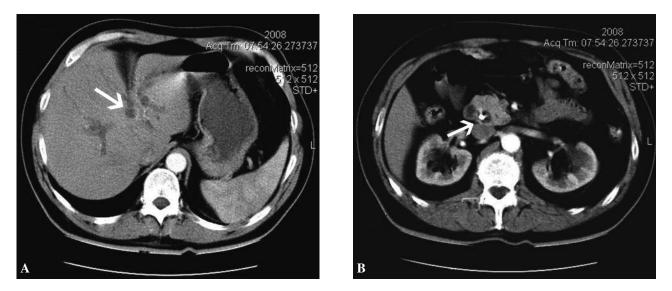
Contrast-enhanced CT scan shows dilatation of the intrahepatic bile duct (A). Dilatation of the extrahepatic bile duct is shown with the plastic stent in place (B).
